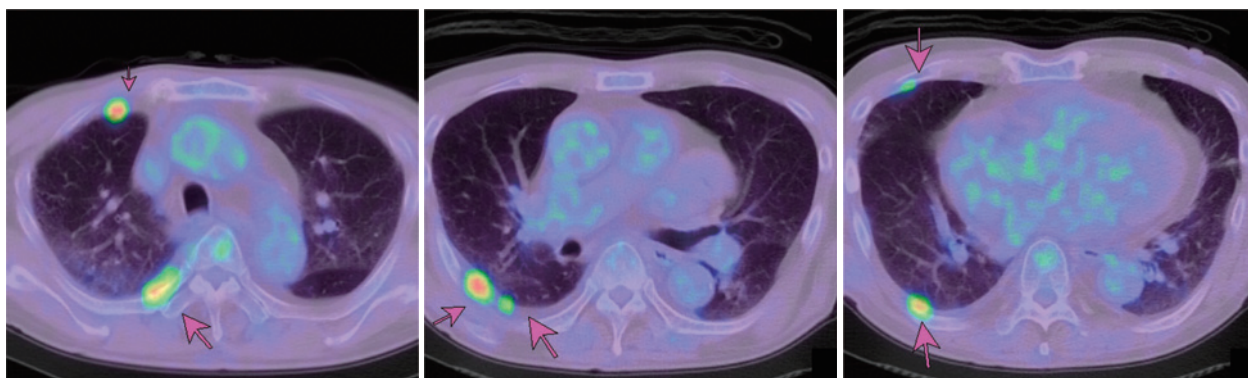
Positron emission tomography-computed tomography (PET-CT) scans of the recurrent tumor. PET-CT image shows strong uptake of FDG in multiple nodules on the right pleura. Lung adenocarcinoma recurred with right pleural metastasis 17 months after surgery.
